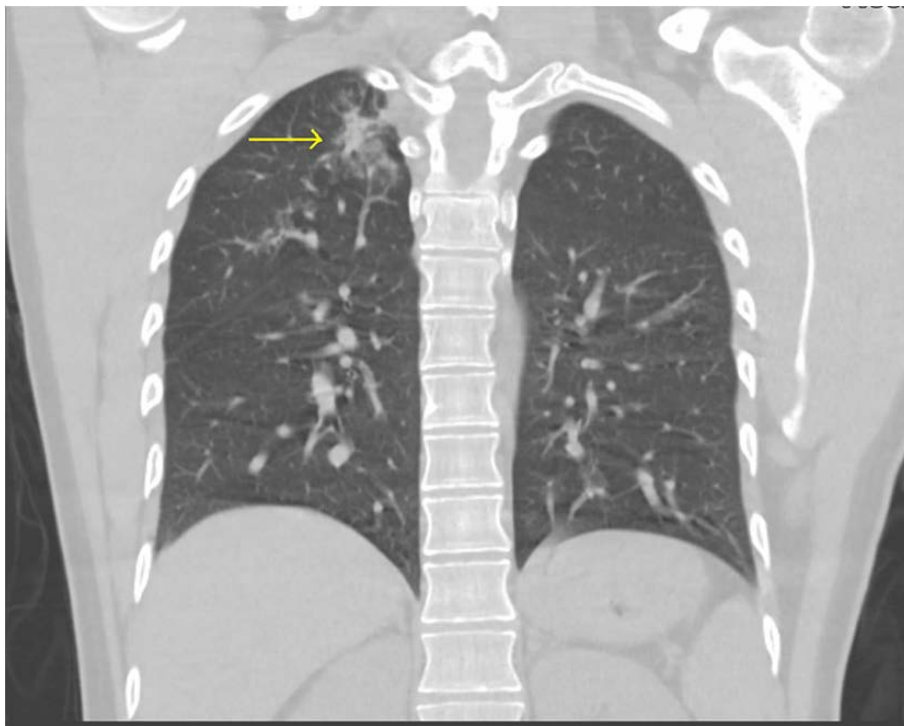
CT Chest: Right apical reticulonodular consolidations. May represent developing infectious processes including mycobacterium avium or tuberculosis (CT: Computed Tomography)
